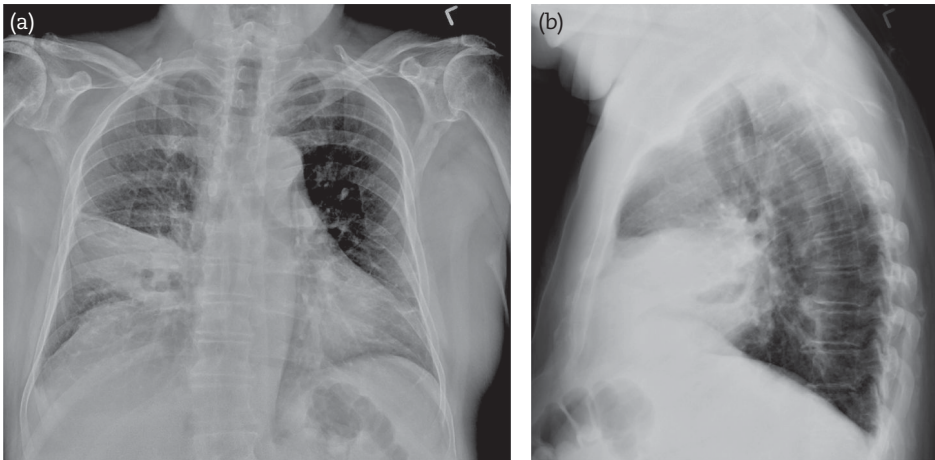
Chest X-Ray images of chest, posterior/anterior and lateral view, right middle lobe infiltrate.
